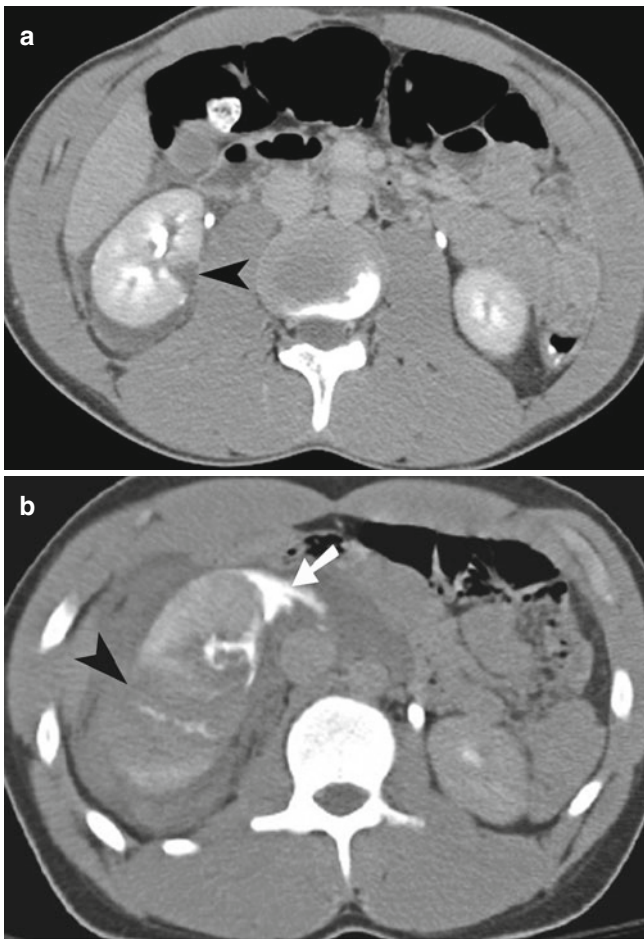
Renal laceration. (a) Axial contrast-enhanced CT demonstrating a grade II laceration (*arrowhead*) with small perinephric hematoma. (b) Axial contrast-enhanced CT demonstrates grade V shattered kidney (*arrowhead*) and extravasation of urine (*white arrow*) into the perinephric space
